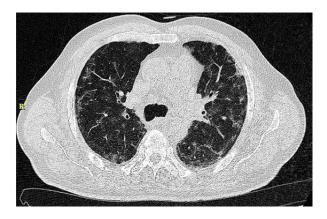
Follow-up chest CT showing partial resolution of lesions in both sides
